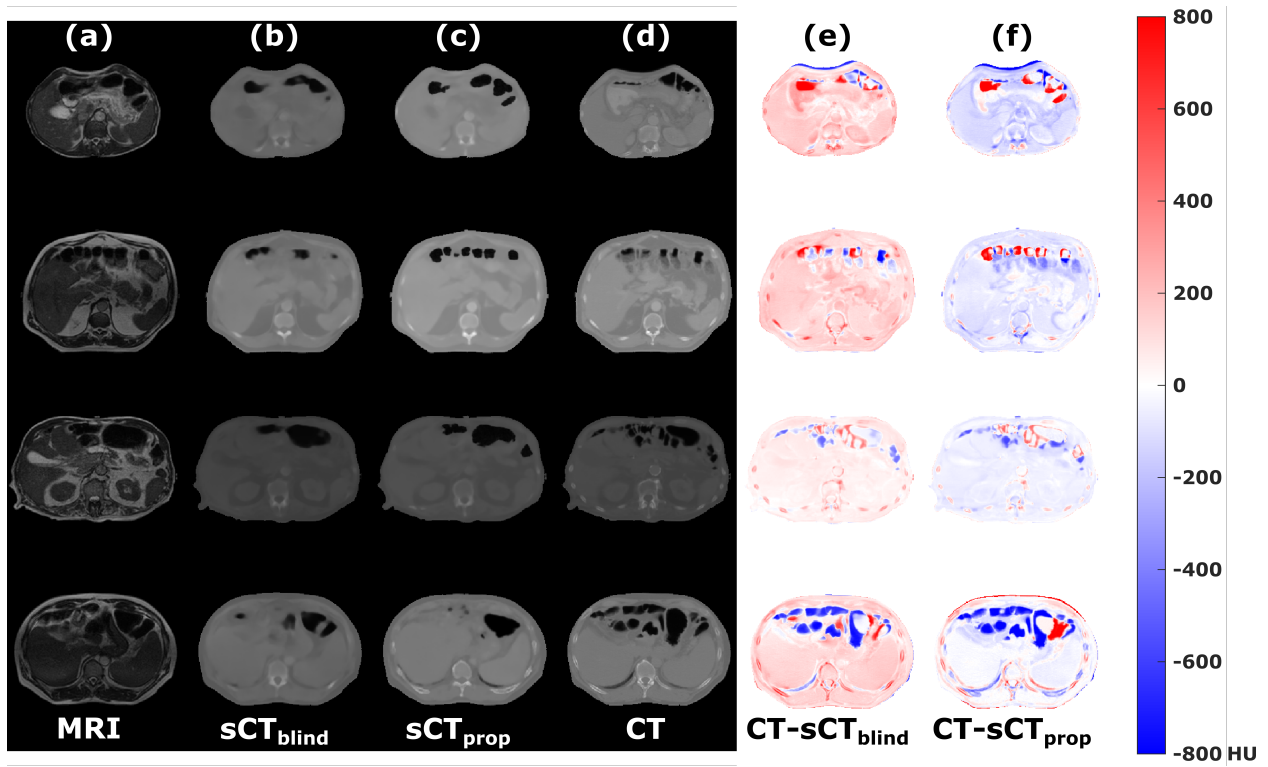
Image comparisons for representative slices of patients in Class 2 characterized by notable differences in the presence of intestinal gas between corresponding MRI and CT scans. Input MR images (a), output sCT images for the blind model (b) and proposed model (c), true CT images (d), and difference maps (e-f) between the true CT images and generated sCT images for the blind and proposed model, respectively. Values in the difference maps are in units of HU.
